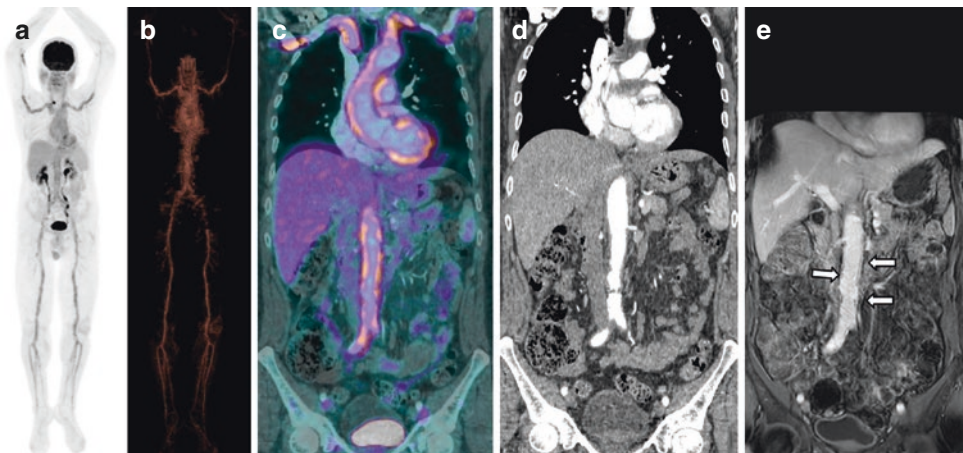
Patient with Takayasu arteritis. ¹⁸F-FDG PET 3D maximum intensity projection (a) and PET 3D volume rendering (b) show intense and pathologic tracer uptake in vascular structures of mediastinum and major arteries of the body. Coronal PET/CT (c) and contrast-enhanced CT (d) display
